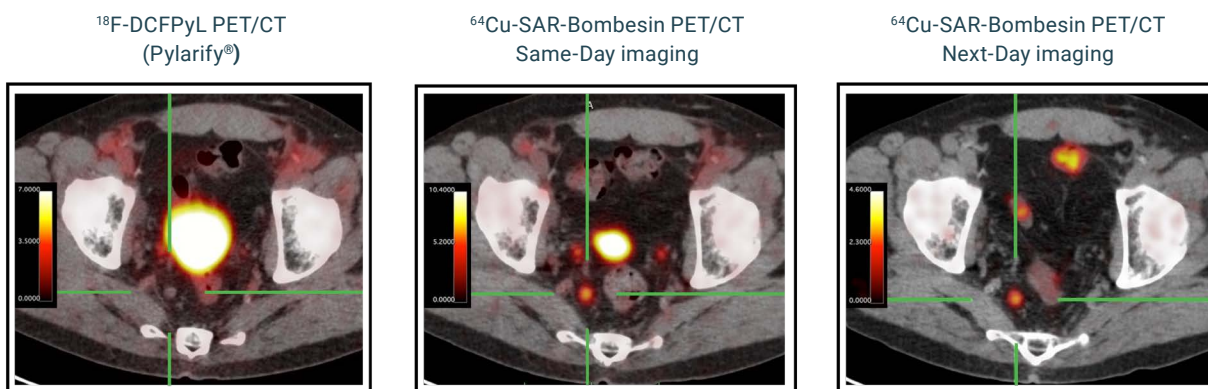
^{64}Cu SAR-Bombesin detected a positive lymph node on scans performed on two different days (same-day and next-day scans). No uptake was observed using ^{18}F -DCFPyL (Pylarify®) PET/CT. A subsequent biopsy, performed and assessed locally by the study site, has confirmed prostate cancer.
